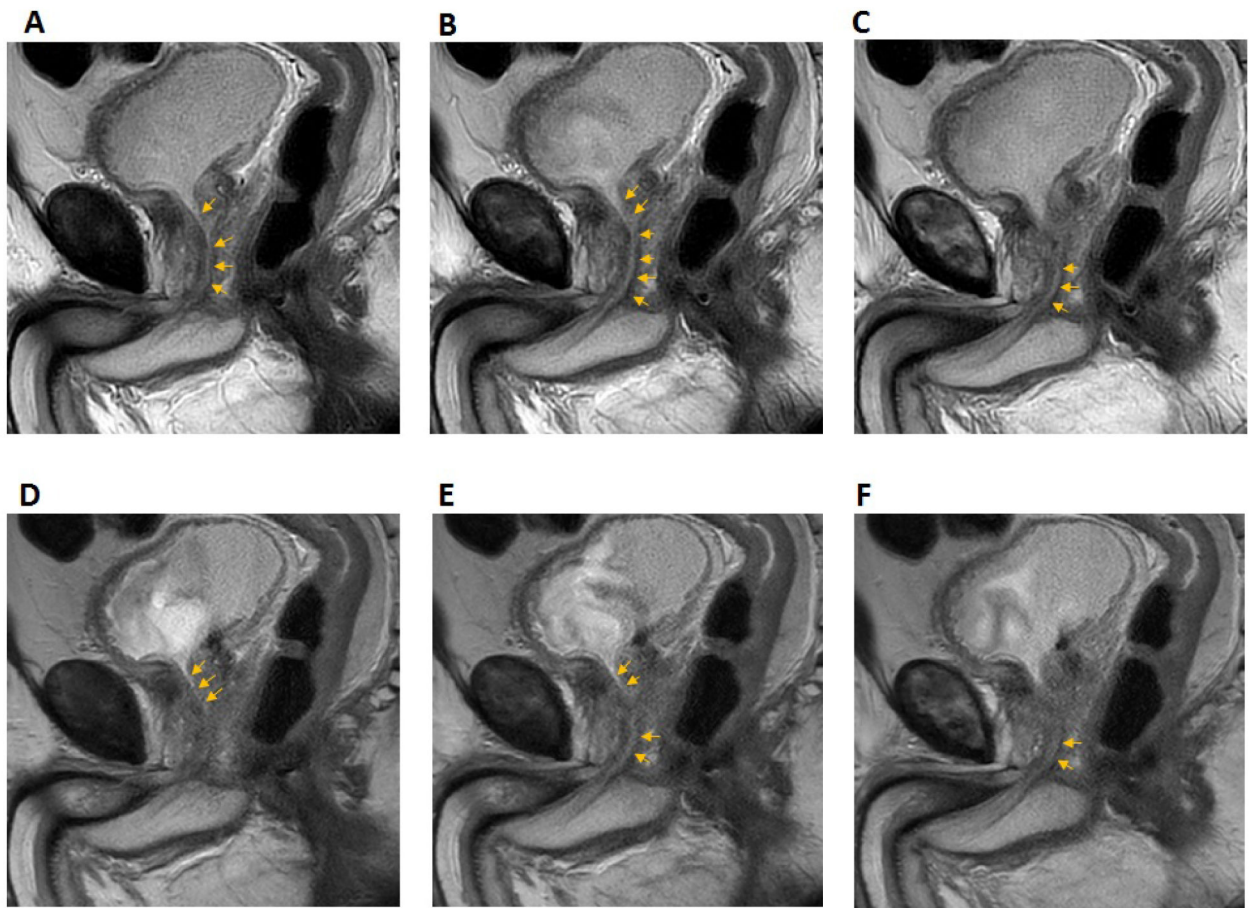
Consecutive T2-weighted sagittal sections through the prostatic urethra (MVXD top row, SSFSE bottom row). See text for scan parameters. Scan times were 2 min 37 s for MVXD and 2 min 55 s for SSTSE. Reader scores for urethral visibility in MVSD vs SSFSE were 5 vs. 3 (Reader 1) and 5 vs. 3 (Reader 2).
